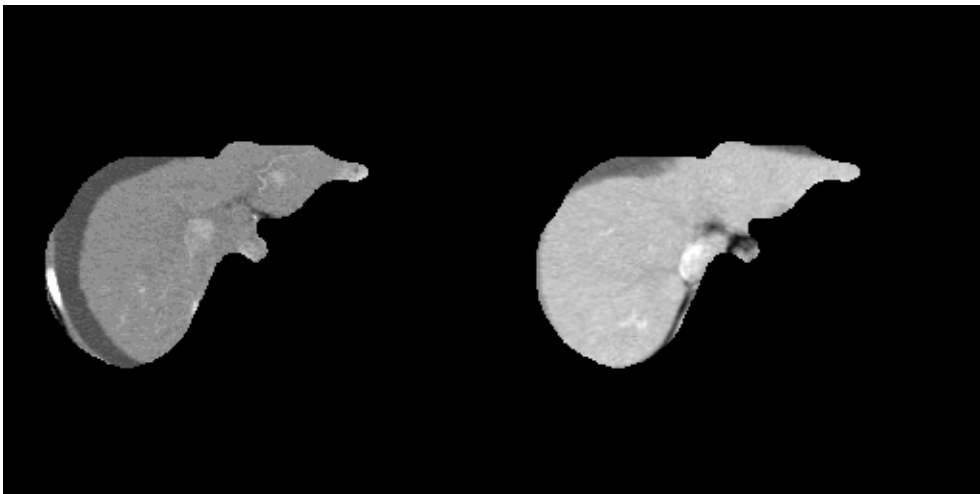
Example images showing registration effect for *CT hepatic phase image registered to MR hepatic image*. On the left we have the registered source image (head-and-hat) multiplied by the target MR mask. On the right we have the registered source image (mutual information) source image multiplied by the target mask. Note the increased amount of non-hepatic structures within the masked region of the head-and-hat image (ribs).
